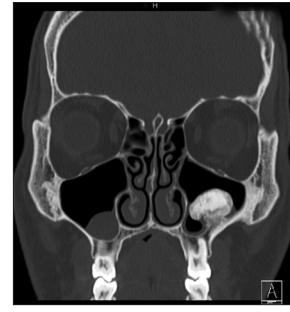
The coronal view of the computed tomography demonstrating, a pedunculated osseous tumor attached to the dorsolateral wall of the left maxillary sinus. The tumor measures 2 cm in diameter and is partially covered by mucosal lining of the maxillary sinus, which is slightly thickened. There is a polypoid mucosal thickening of the right maxillary sinus
